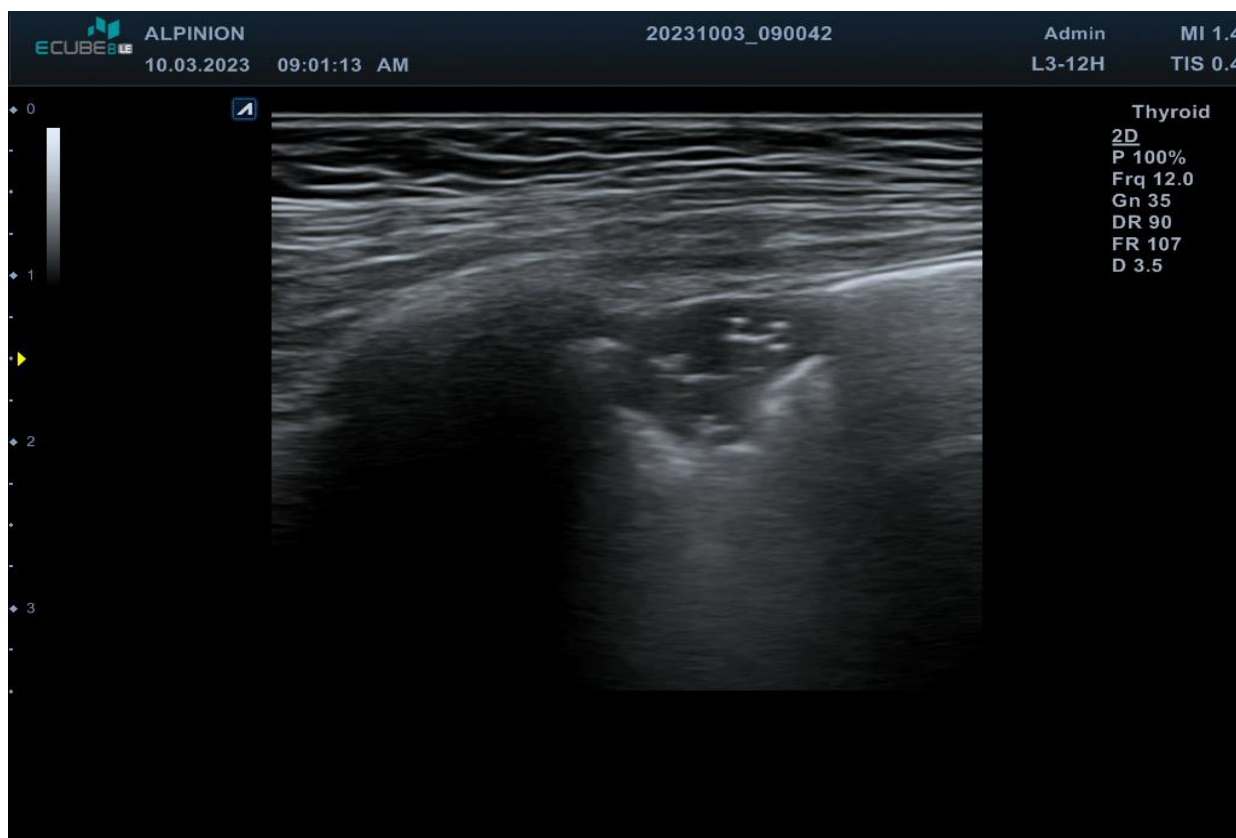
lung ultrasound showing consolidation
